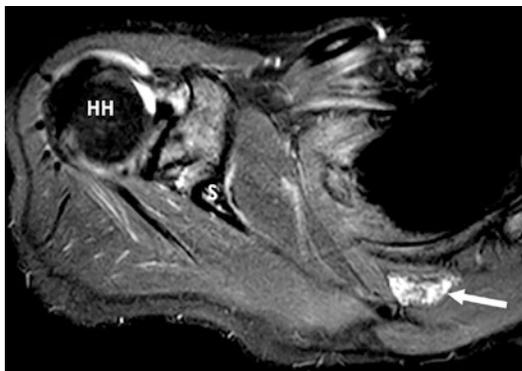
Preoperative MRI (T2 weighted) of a patient with SSS showing inflamed fibrotic scar tissue between the superomedial scapula angle and the thorax (*white arrow*). HH humeral head, S scapula
